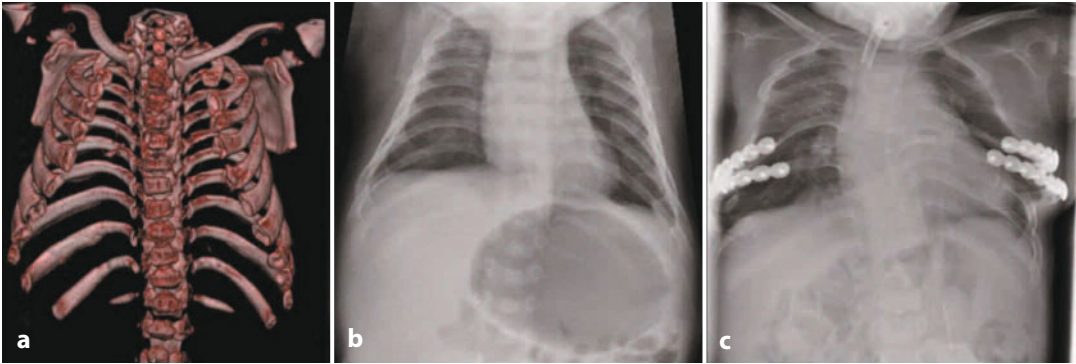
Jeune syndrome. CT reconstruction showing short, wide and horizontal ribs with reduction of intrathoracic capacity (a). Chest radiograph demonstrating the disproportion between the thoracic and abdominal diameters and the rib anomalies mentioned above (b). The result of bilateral thoracic expansion (c)
